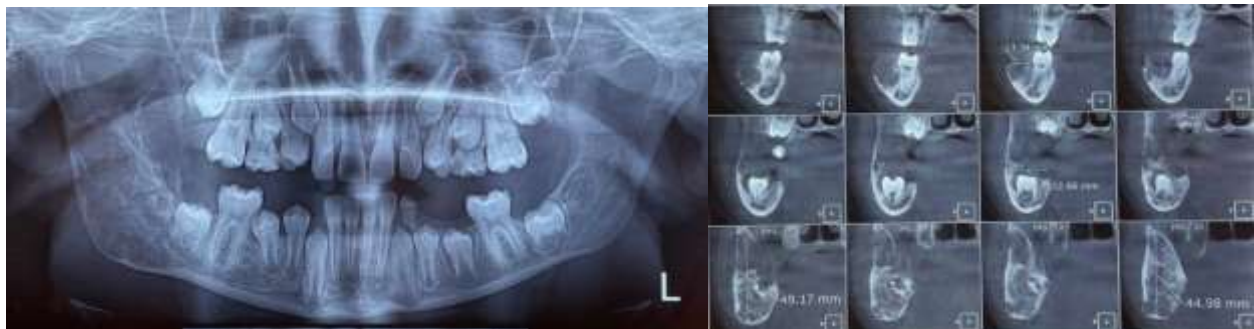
a: Pre-surgical panoramic view. The patient was in the mixed dentition stage demonstrating a radiopaque lesion in the right mandibular ramus, b: Pretreatment cone-beam computed tomography (CBCT) images demonstrating an extensive intraosseous lesion involving the right mandibular ramus
